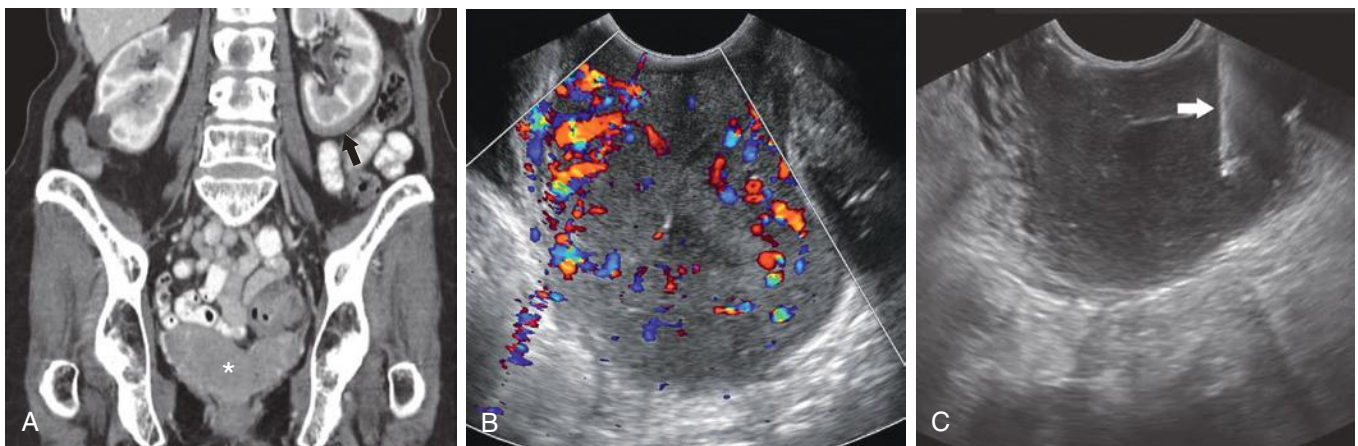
Pelvic lymphoma diagnosed by means of transvaginal ultrasound-guided biopsy. A, Reconstructed coronal image from contrast-enhanced computed tomography scan. Note lobulated soft tissue mass (*asterisk*) adjacent to the vaginal cuff. The uterus is surgically absent. It was deemed too difficult to safely obtain a large core tissue sample of this mass via a percutaneous approach. Also note thin rim of lymphomatous tissue surrounding the left kidney (*arrow*). B, Transvaginal ultrasound image with color Doppler interrogation shows the moderately echogenic solid pelvic mass with peripheral vascularity. C, Using real-time transvaginal sonographic guidance, biopsy of the solid pelvic mass, using an 18-gauge core biopsy needle (*arrow*), was successfully performed without incident.
